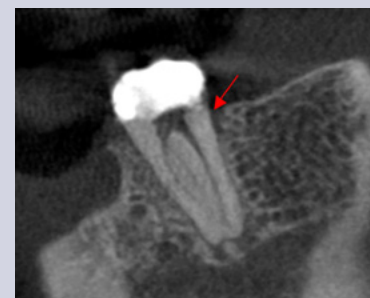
Sagittal CBCT slice of tooth #18 revealing an isolated osseous radiolucent defect along the mid-distal aspect suggestive of a root fracture.
